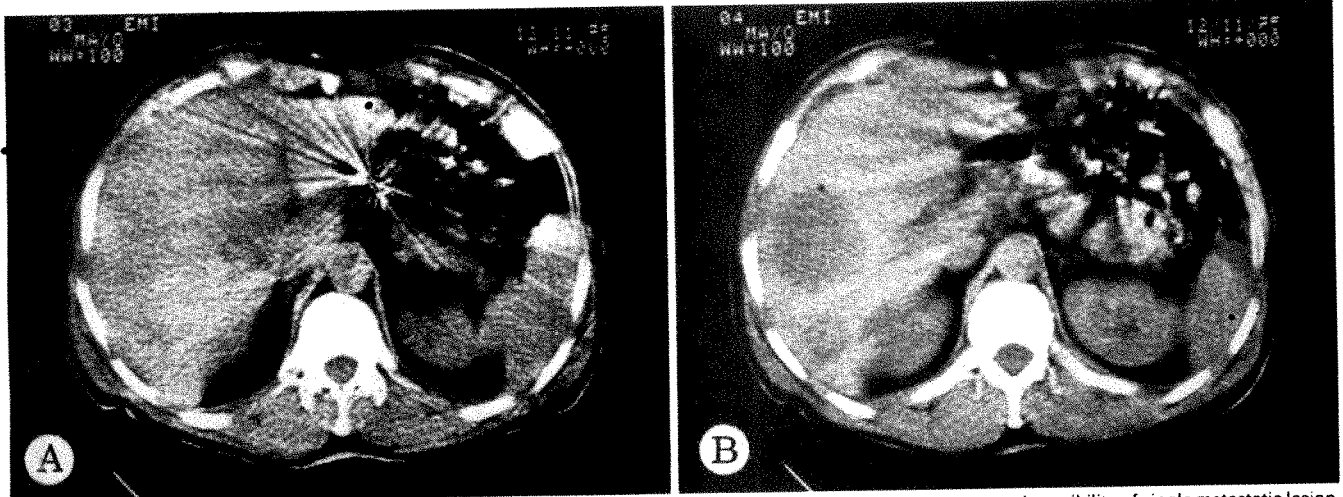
CT scans of 48-year-old man 7 months after resection of gastric leiomyosarcoma. Liver nuclear scan suggested possibility of single metastatic lesion. A, Faint, low density mass in medial portion of right lobe of liver, partially obscured by streaking artifact due to motion of metallic surgical clip. B, One large and one small low density metastasis in posterior portion of right lobe of liver. Grade 2 metastatic leiomyosarcoma confirmed by liver biopsy.
